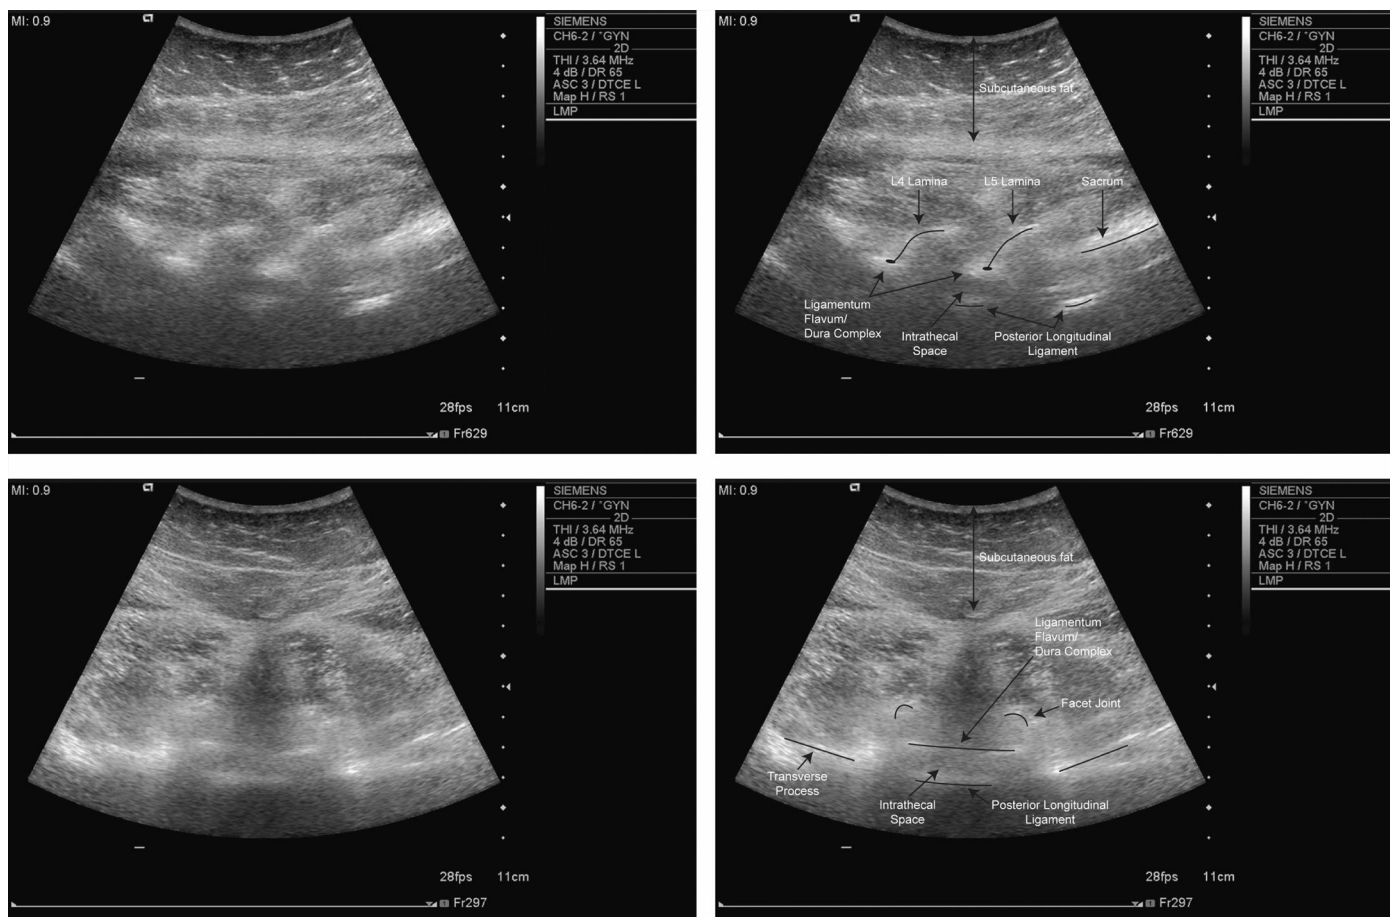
Epidural ultrasound images in a patient with BMI > 40 kg/m². Top left: paramedian view. Bottom left: transverse view. Right: images repeated with landmarks identified. Note the much poorer quality images obtained in the obese patient compared with those often published from non-obese subjects, due to the layer of subcutaneous fat.
